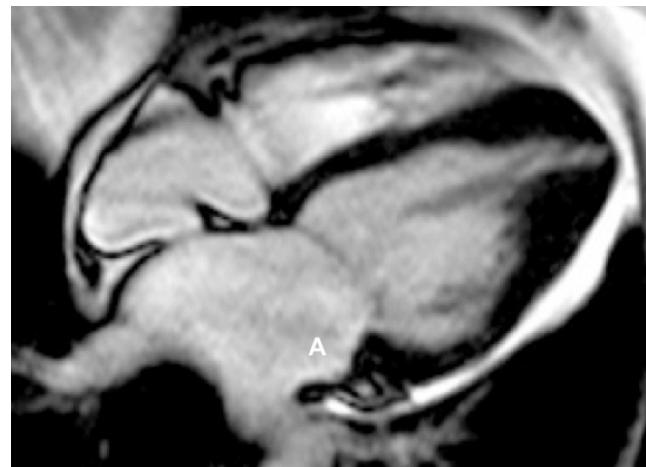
Four-chamber MRI image at end-diastole in a patient who was found to have normal wall thickness on routine 2D echo. Cardiac MRI, however, demonstrated LV wall thickening exclusively in the apical region of the left ventricle, usually less accessible by echocardiography.
